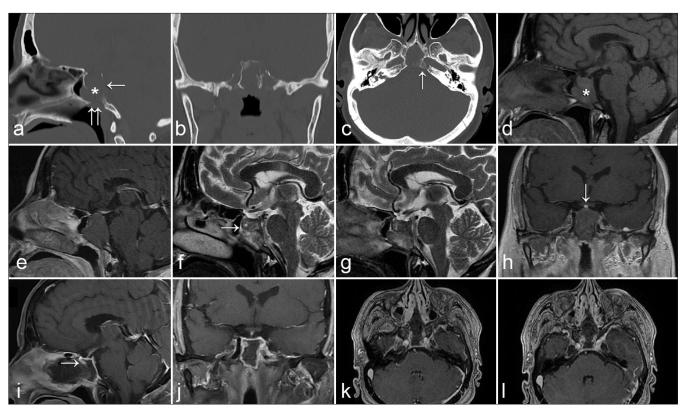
Neuroimaging findings in Case No. 2. (a-c) Preoperative computed tomography scans revealed extensive bone erosion, including the clivus (a single arrow), sellar floor (an asterisk), sphenoid sinus floor (a double arrows), and left petrous apex (c, arrow). (d-h) Preoperative magnetic resonance imaging (MRI) (d-h) revealed a T1-weighted isointense expansile lesion filling the sphenoid sinus cavity and the sella turcica (d, asterisk). The lesion was seen to have almost completely eroded and replaced the clivus. Very faint marginal enhancement is seen post-gadolinium injection. (e) No enhancement of the lesion was present. (f-g) On T2-weighted images, the lesion displayed mixed iso- and hyper-intense signals. Mucus within the remaining small cavity of the sphenoid sinus (f, arrow) and (h) compressed pituitary stalk (h, arrow) are observed. Postoperative contrast-enhanced (i) sagittal, (j) coronal, and (k-l) consecutive axial T1-weighted MRI demonstrated a gross total resection. The normal pituitary tissue is seen (i, arrow).
